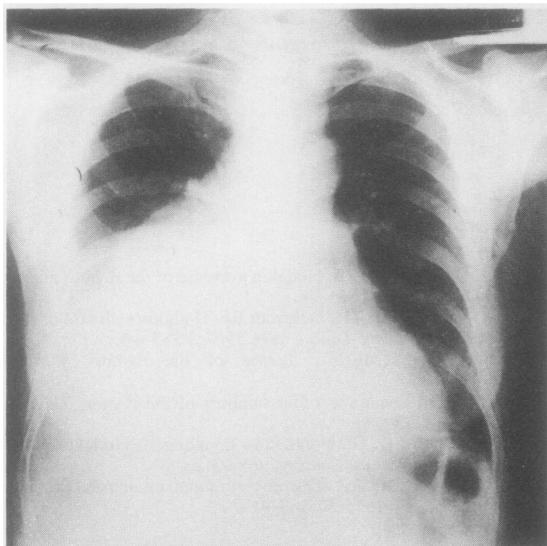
Chest radiograph showing a right paramediastinal shadow with a sharp outline, caused by an encapsulated mediastinal haematoma.
